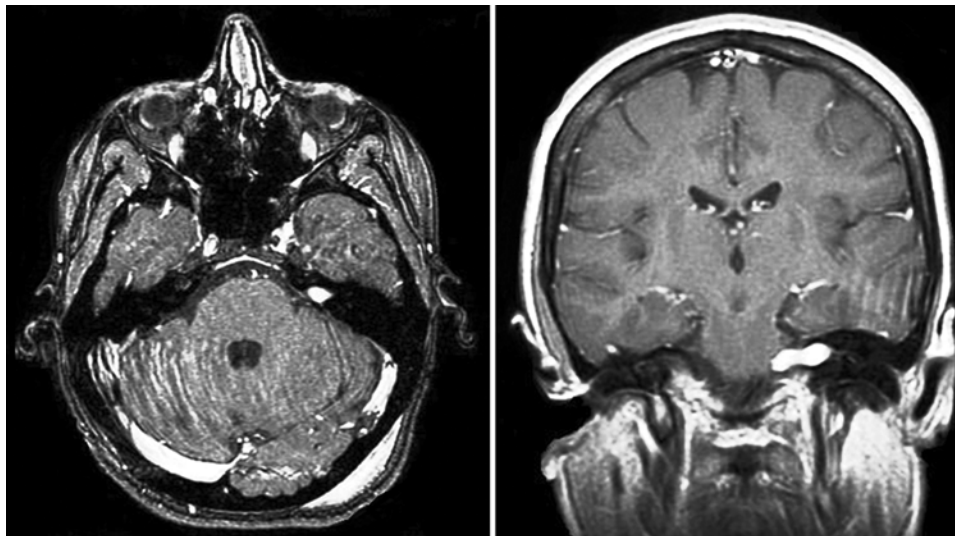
Contrast-enhanced T1-weighted MR images demonstrating small VSs with diameters of 1 cm (left) and 2 cm (right). Systematic review of mostly Class 3 evidence suggests that the chances of facial nerve preservation after microsurgery is significantly higher in tumors 1.5 cm or less in diameter than in those with a diameter of more than 1.5 cm.
